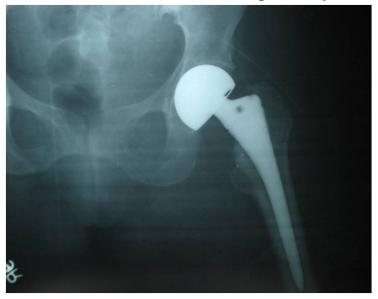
Post operative radiograph after hemiarthroplasty.
